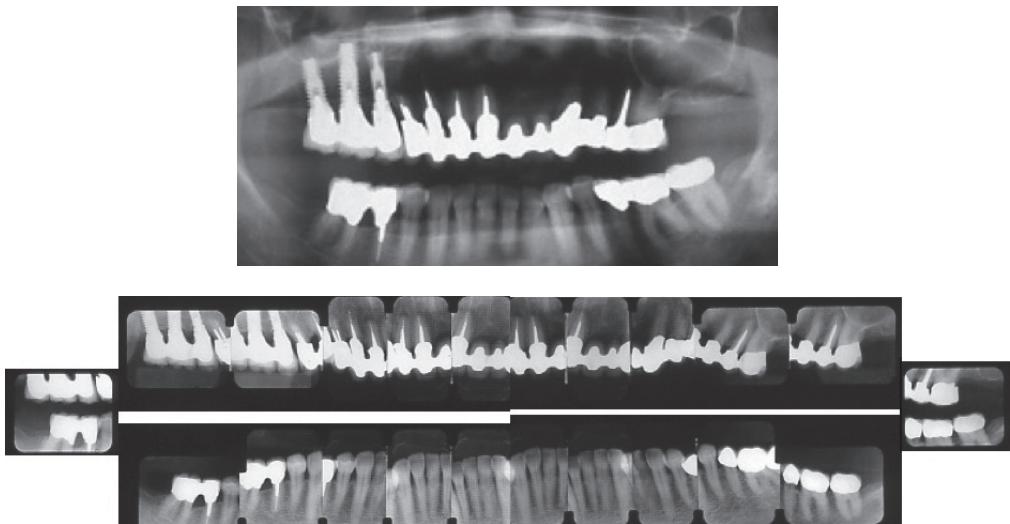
Case 6 - Radiographs 5 years after completion of treatment
